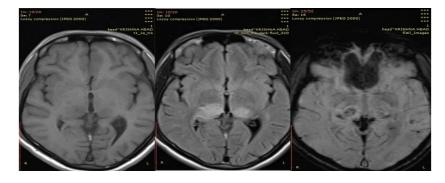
Area of altered signal intensity (~6.5 x 3.0 x 2.6 cm) hyperintense on T2WI/FLAIR (A), hyperintense on T1WI (B) noted in the right parietal-temporal region with the corresponding area showing blooming on SWI (C) suggestive of Intra parenchymal hematoma (blood in acute to the subacute stage) with surrounding edema.
